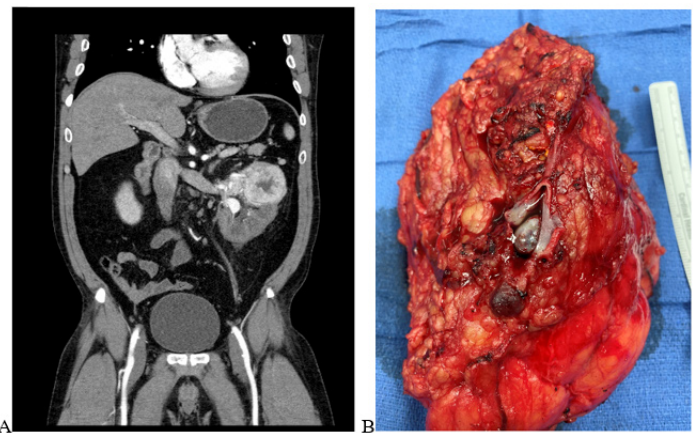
A) Computed Tomography scan (Patient #2) showing a renal cell carcinoma with tumor thrombus extending into the left renal vein. B) Large left renal mass with tumor thrombus into the left renal vein (Patient #2).
